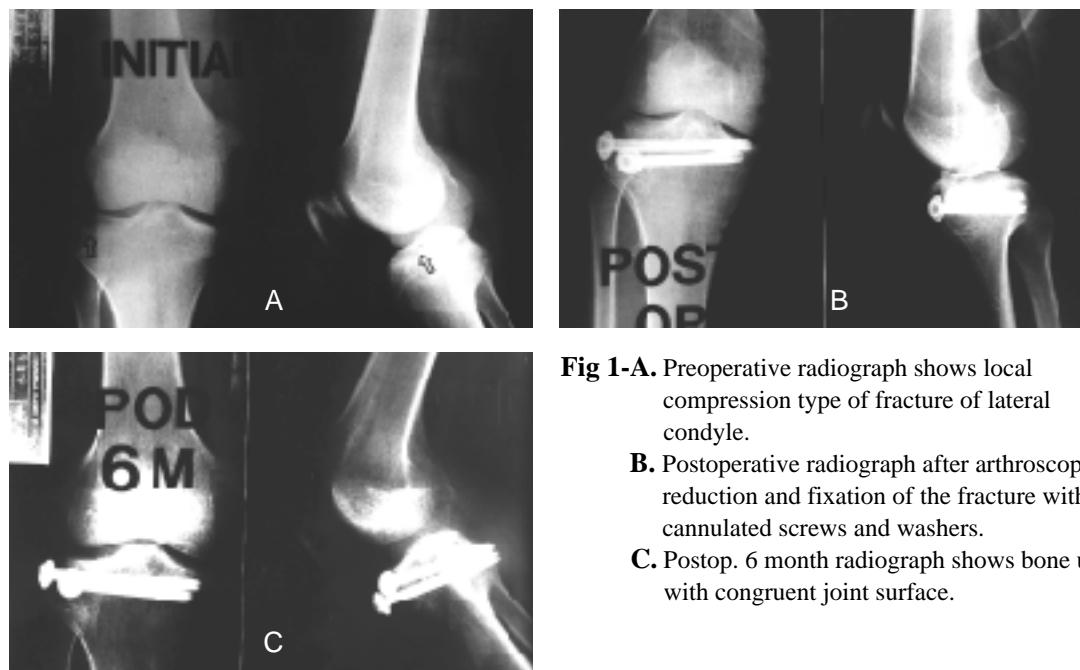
Preoperative radiograph shows local compression type of fracture of lateral condyle.
